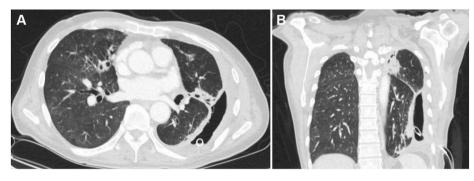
Axial (A) and Coronal (B) thoracic computed tomography (CT) images showing complicated hydropneumothorax due to loculated empyema with chest tube. However, tract of Bronchopleural fistula (BPF) is not apparent.
